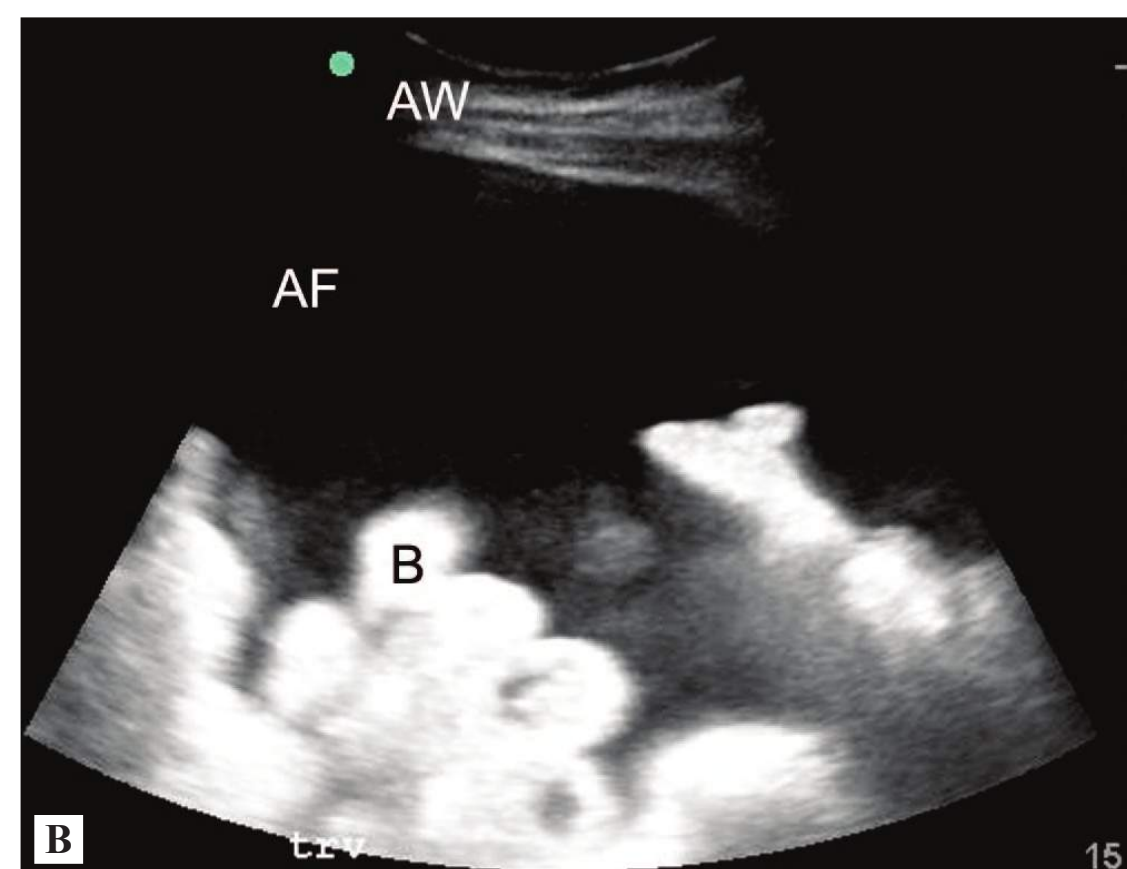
■ Ascites on Ultrasound. Ascitic fluid (AF) seen between the abdominal wall (AW) and bowel (B) on this bedside ultrasound. (Photo contributor: Jeremy Simpson Boyd, MD.)
